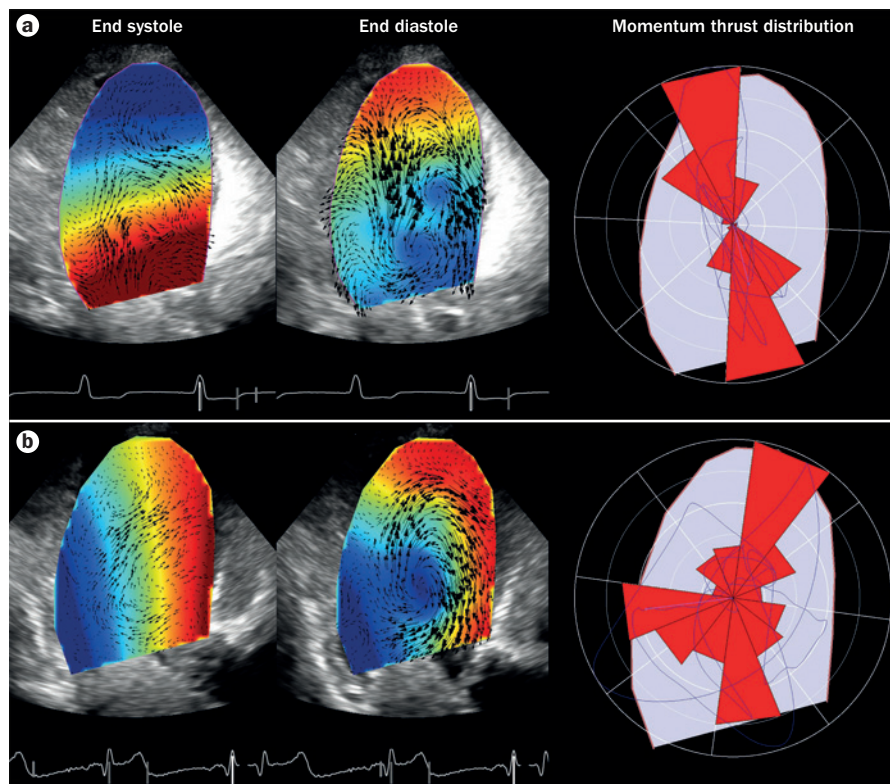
Longitudinally directed intraventricular pressure gradients are markers of normal left ventricular function. Echocardiographic recordings from a patient who responded, with reverse remodelling, to cardiac resynchronization therapy (biventricular pacemaker). a | Under normal conditions (pacemaker on), the various segments of the left ventricle are physiologically dyssynchronous. Their lack of homogeneity in space and time bears longitudinal pressure gradients inside an asymmetric cavity with its individual shape dimensions, and transmural stresses. Normal flow develops base-to-apex suction at the onset of diastole and apex-to-base thrust at the onset of systole. b | A few heart beats after pacing deactivation (pacemaker off), small differences in segmental mechanics are associated with nonphysiological blood motion with the onset of transversal pressure gradients. Diastolic filling impacts on lateral segments and regional systolic contraction provokes thrust on facing walls. Altered filling-emptying dynamics give rise to pathological changes in space-time occurrence of tissue stresses, possibly triggering the loop of LV remodelling. Red indicates high pressure and blue indicates low pressure.
